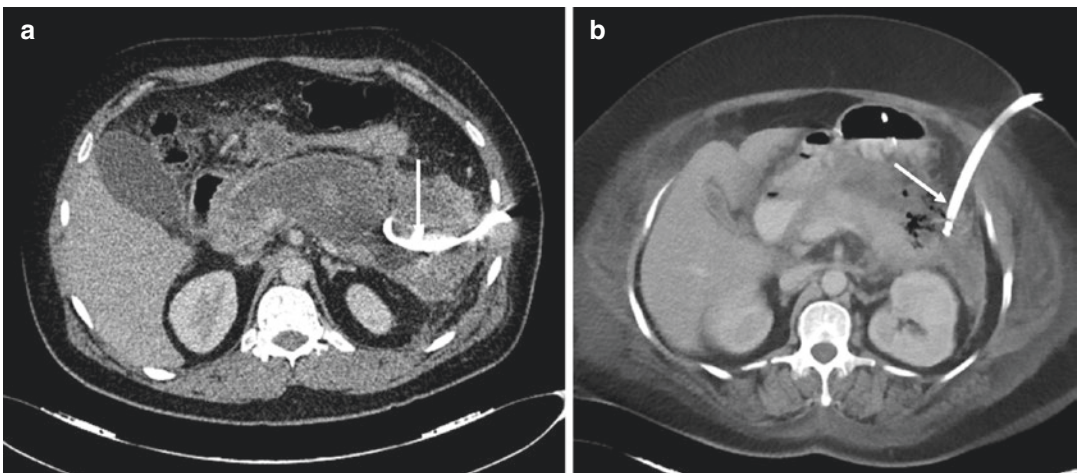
(a) Retroperitoneal catheter insertion along the long axis of the pancreatic collection was performed under CT guidance (arrow). (b) A transperitoneal catheter
